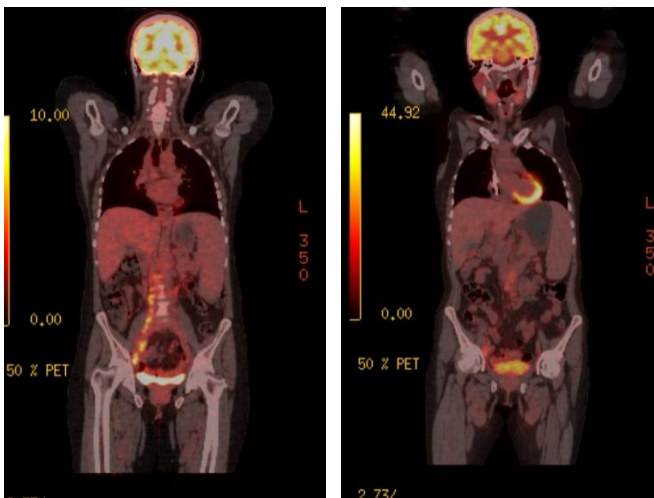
PET/CT images of the patient while on maintenance lenalidomide therapy (Slight involvement of lymph nodes in the right upper paratracheal area with significant regression in abdominopelvic and mediastinal lymph nodes)
